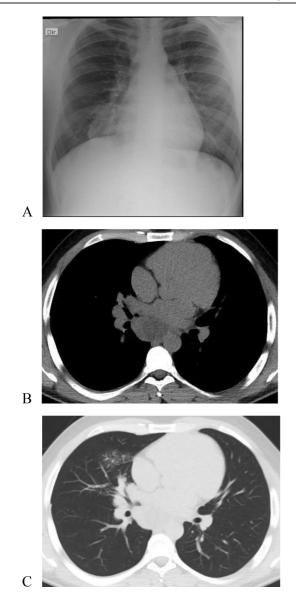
(Original images) (A) Chest x-ray with right mediastinal enlargement. (B-C) Chest computed tomography, depicting an infracarinal mediastinal mass and a right middle lobe consolidation. (Original images).
